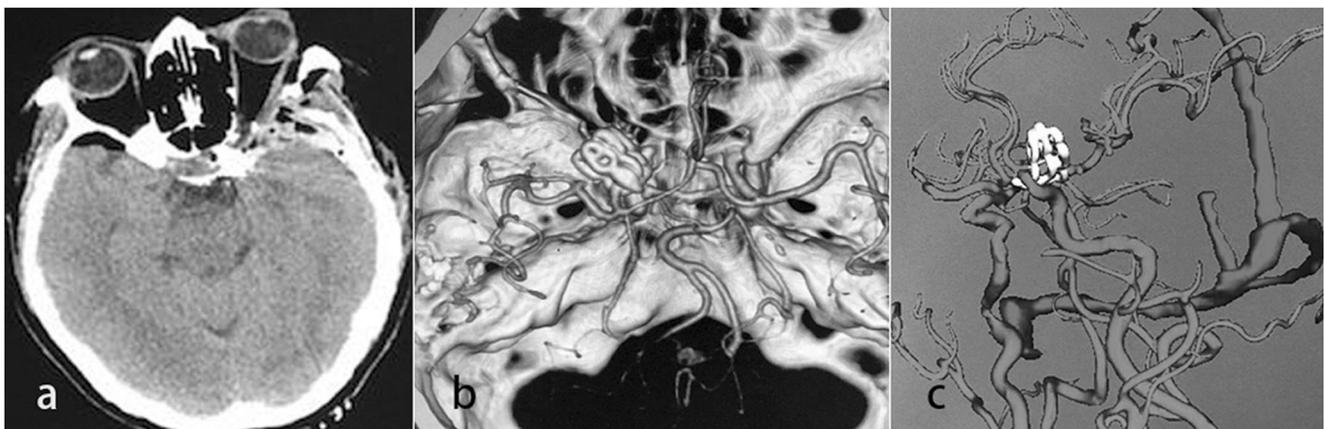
Postoperative imaging studies. a CT scan indicates neither brain infarction nor intracranial hemorrhage. b and c CT angiography indicates a complete aneurysm obliteration and no compromise of the parent artery
